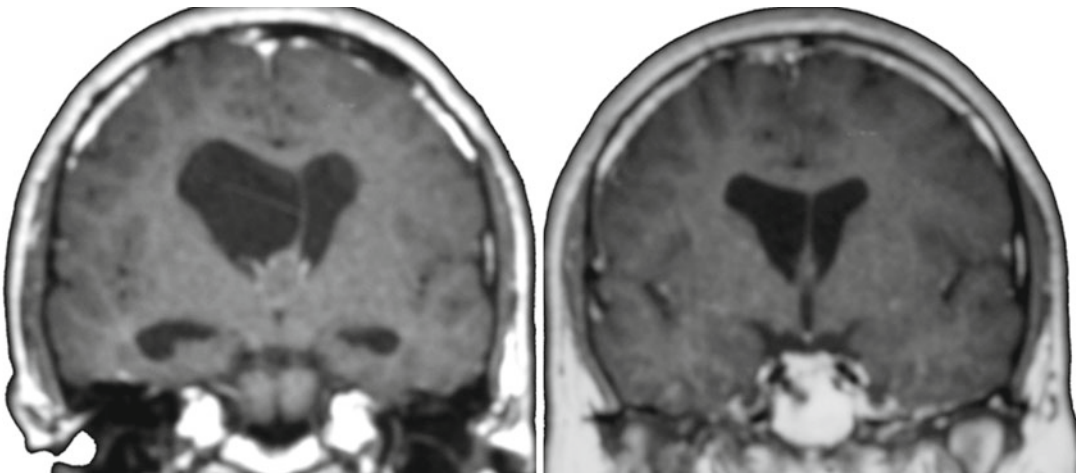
Preoperative (*left*) and postoperative (*right*) coronal T1w MR image of a patient with colloid cyst, which was removed endoscopically
